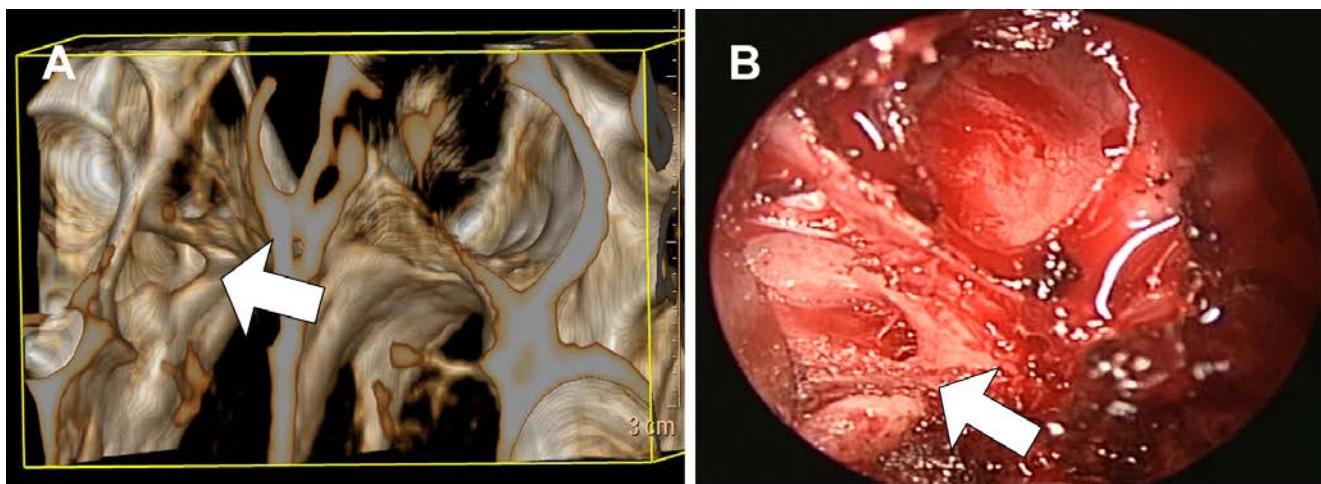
The gap (white arrow) between the sphenoid bone and sphenoid process of the palatine bone is shown on A: a pre-operative 3D reconstruction CT image; and B: an intraoperative endoscopic view.
